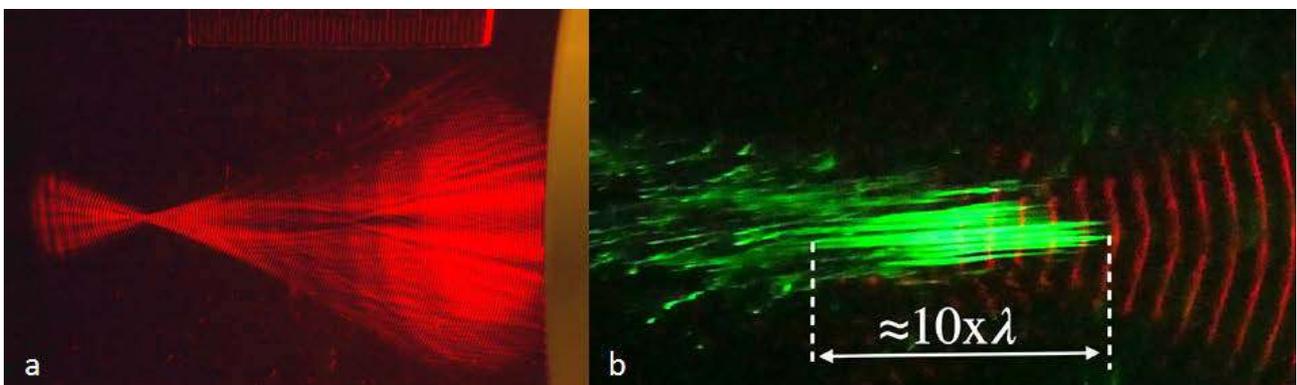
Fig a) Stroboscopic image of a 3.1 MHz focussed wave field. Note the braided interference pattern. Scale at top of image is 45 mm. Fig b) Cavitation bubbles in water at 130 W ultrasound power are illuminated by a green laser (not pulsed). Bubble track length within shutter time (1/16000 s) allows estimation of bubble speed to 80 m/s.
